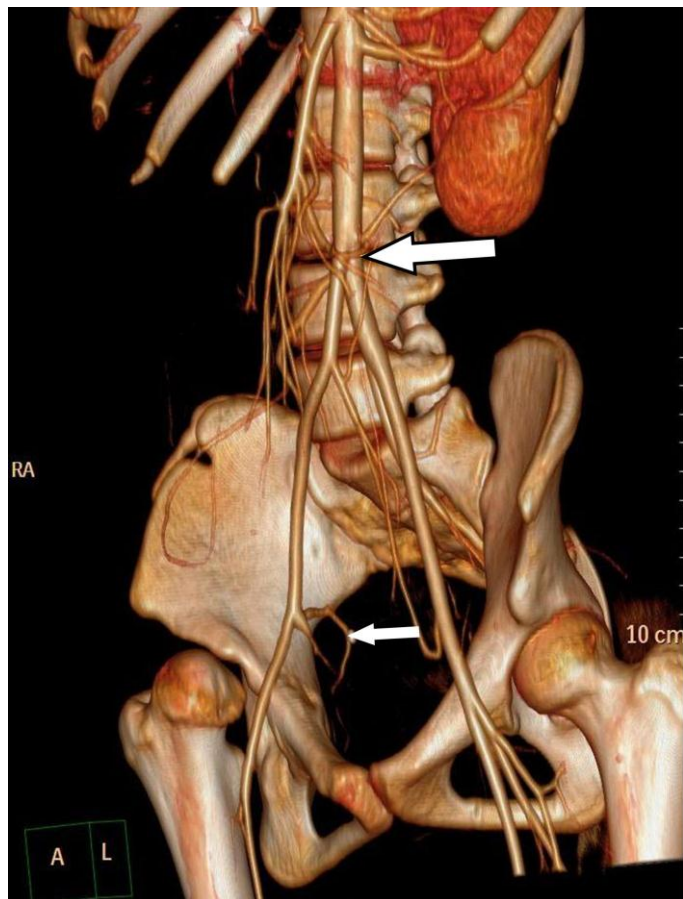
(top): 12 year old female with urinary bladder and right renal agenesis. Contrast enhanced CT abdomen in arterial phase with volume rendered image shows high bifurcation of abdominal aorta (large arrow) and artery corresponding to posterior trunk of right internal iliac artery arising from right external iliac artery (small arrow). Protocol: Philips Brilliance 64 slice CT 200 mAs, 120 kV, 3 mm slice thickness, 45 ml Omnipaque.
